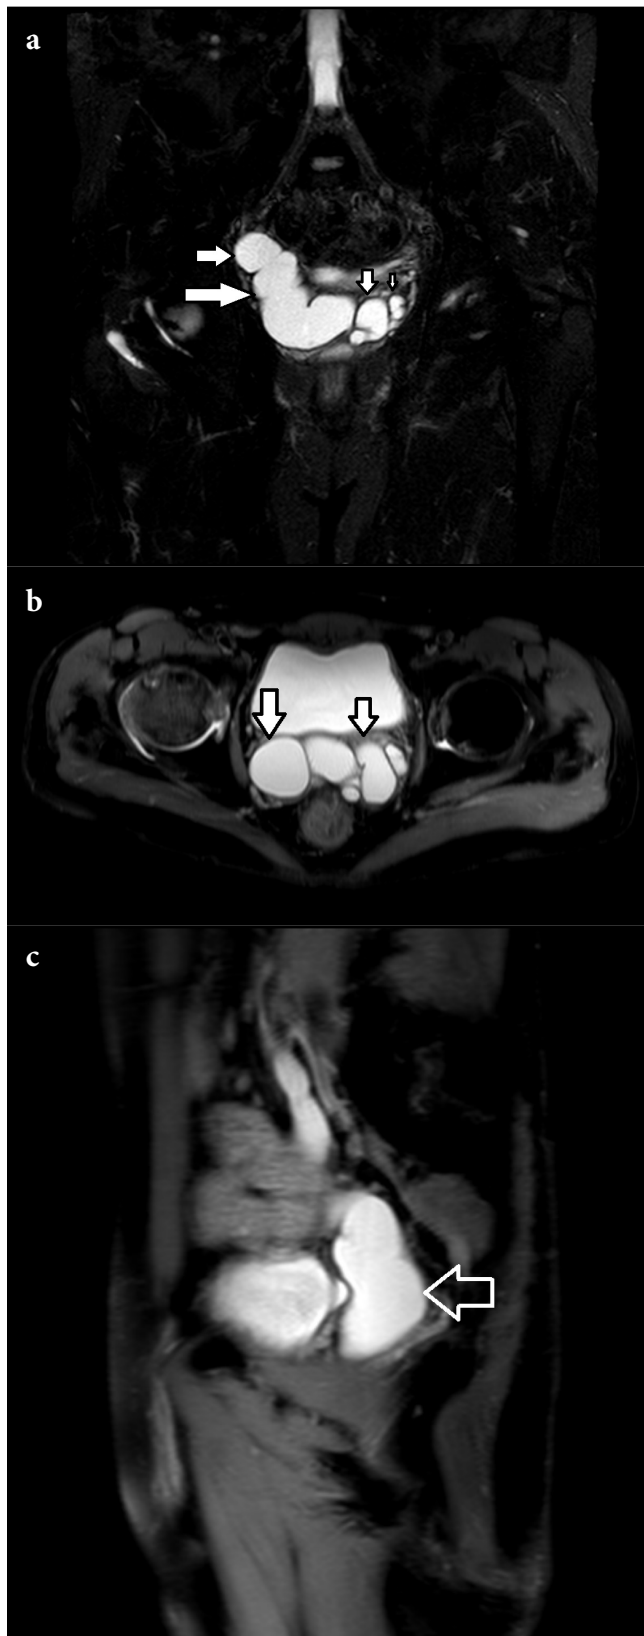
On T2-weighted fat-sat coronal (a) and axial (b) images; Tubular enlargement was detected in the cystic structure starting from the bilateral prostate central to the lateral and extending from the bladder inferior to the right.
